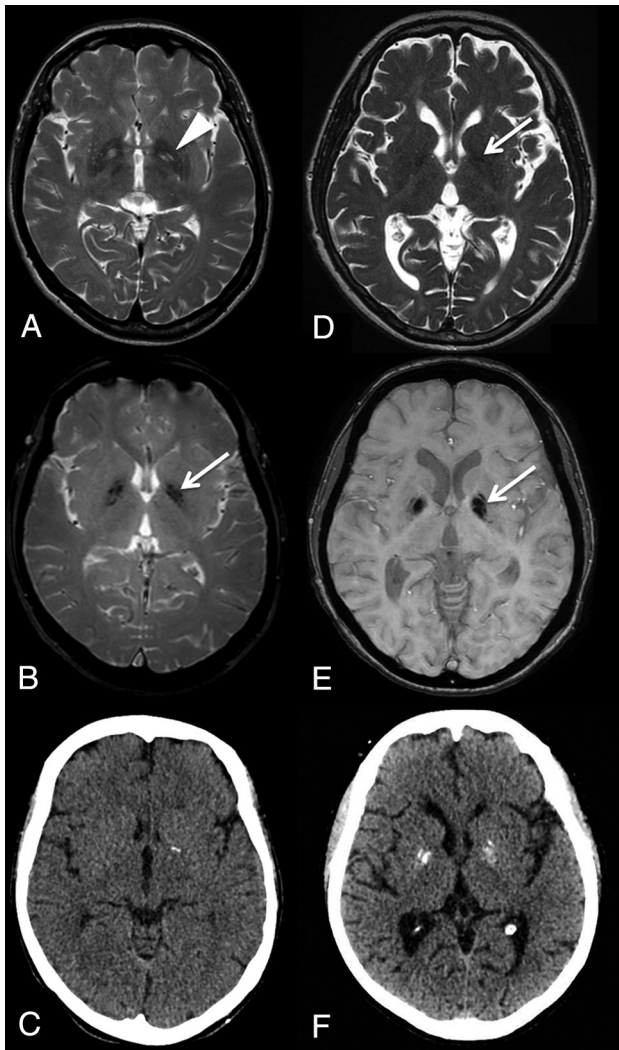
Basal ganglia abnormalities of patients 4 (A–C) and 7 (D–F). Axial T2- (A and D) and magnetic susceptibility- (B and E) weighted images show bilateral hypointensities of the pallidum (arrows) and the eye-of-the-tiger sign (arrowhead). Axial CT scans (C and F) show unilateral (C) and bilateral (F) calcifications.
